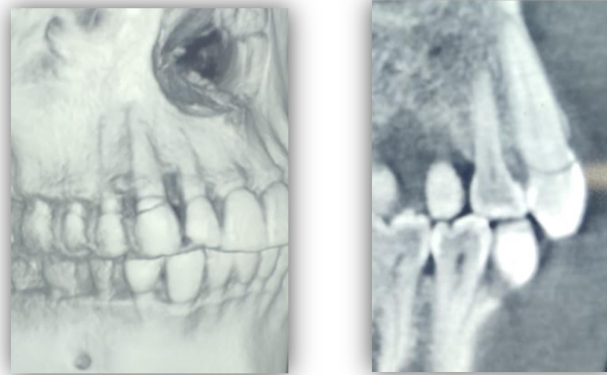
Preoperative CBCT images
